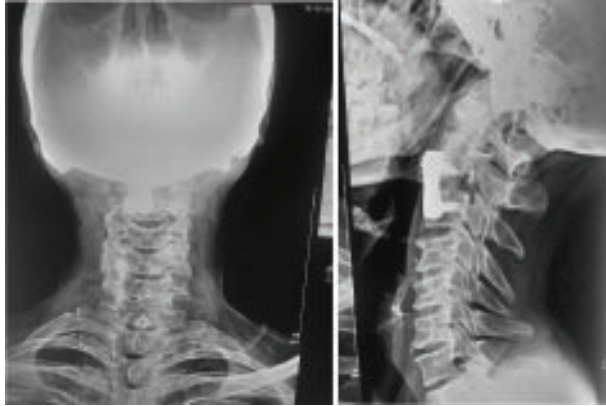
Postoperative x-ray of cervical spine
